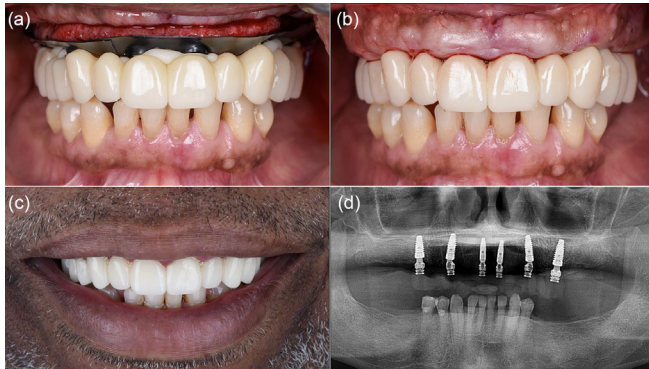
Immediate loading procedure. (a) An immediate loading device and a closed-mouth pickup technique were used to complete an interim implant-supported complete-arch fixed dental prosthesis (ISCFDP). (b) Postsurgical intraoral view of the interim ISCFDP in situ. (c) Postsurgical extraoral smile view of the interim ISCFDP. (d) Panoramic radiograph.
